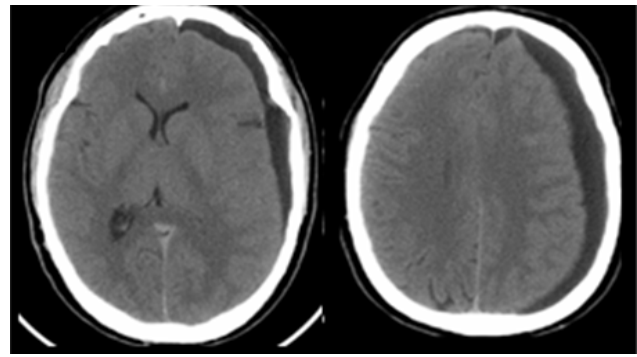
Brain CT after two months, revealing left subdural hygroma enlargement with mass effect and midline shift
